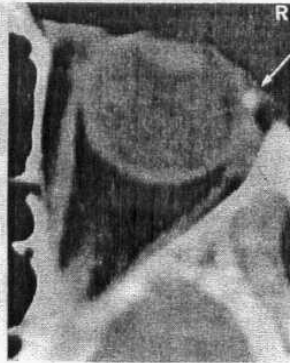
Axial CT of an extraocular F.B. (arrow) anterior to the anterior attachment of the lateral rectus.
